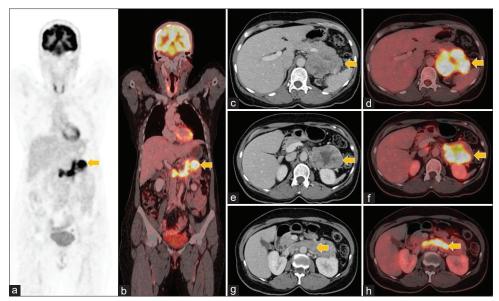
Staging ¹⁶F-fluorodeoxyglucose positron emission tomography–computed tomography scan coronal positron emission tomography (a), fused coronal positron emission tomography–computed tomography (b), and corresponding transaxial images (c-h) showing fluorodeoxyglucose-avid large heterogeneously enhancing left adrenal lesion with tumor thrombus infiltrating the left renal vein and adjacent inferior vena cava
